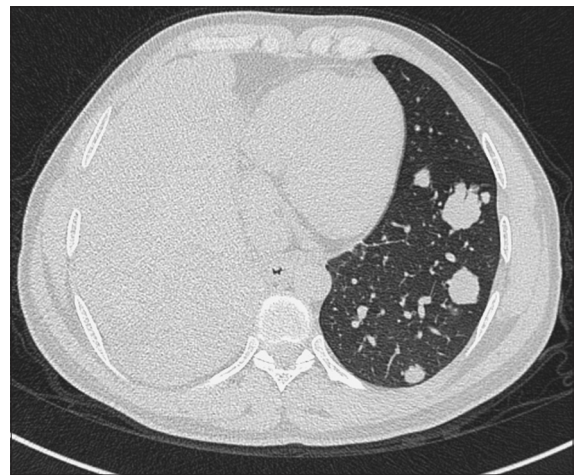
Contrast enhanced computed tomography thorax with the lung window
